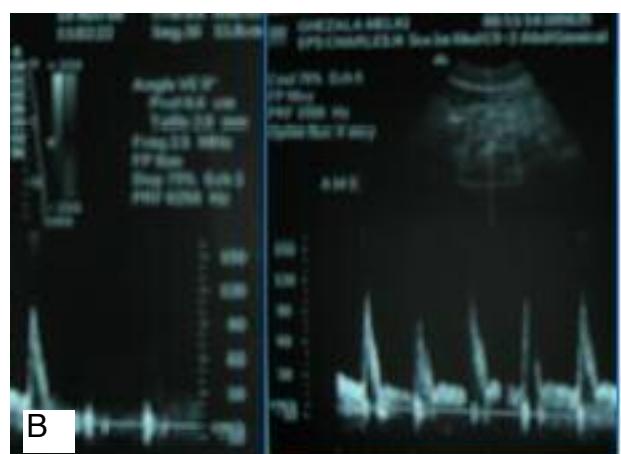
(a/b/c) : a/ 3-D reconstruction CT angiography, revealing a stenosis involving the proximal celiac artery compatible with median arcuate ligament syndrome
